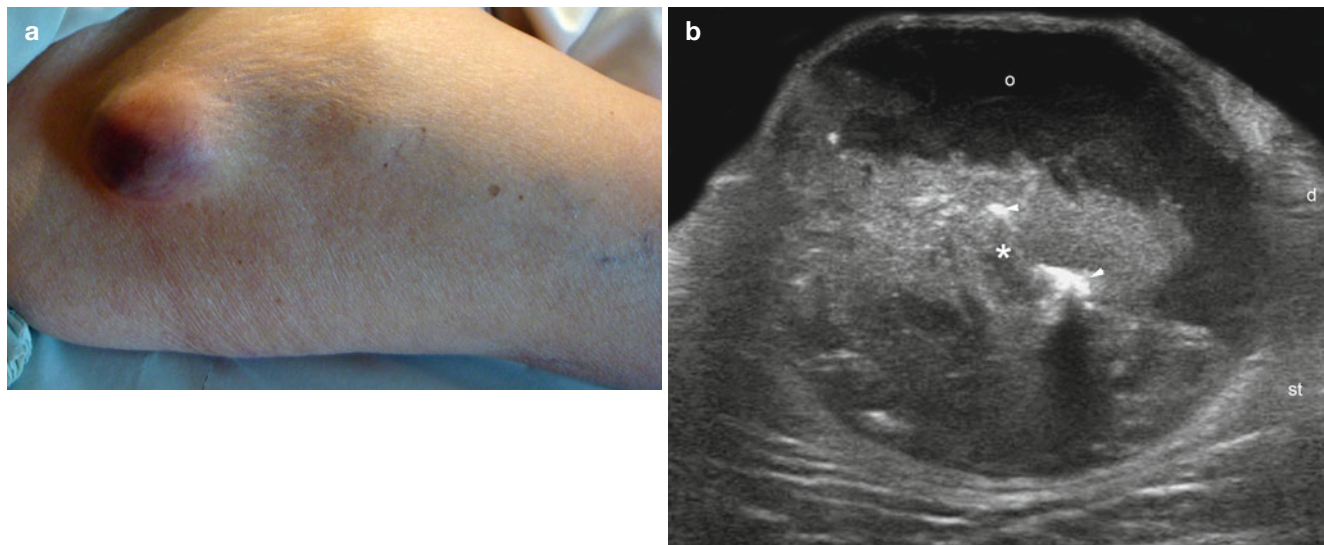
(a–f). Cystic pilomatrixoma. (a) Erythematous lump in the lateral aspect of the right thigh. (b–d) Grey scale ultrasound images (b transverse view; c longitudinal view; d zoomed longitudinal view) demonstrate a mixed echogenicity mass in the dermis and subcutaneous tissue. There is a hypoechoic solid area (*) with a hyperechoic spot that corresponds to
